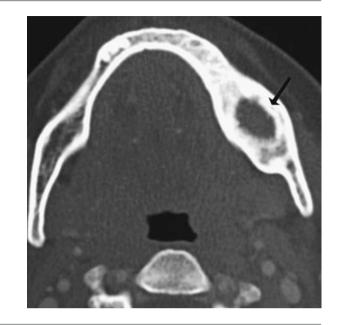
CT scan showing ossifying fibroma of the left ramus of the mandible in a young patient with HPT-JT (arrow)
